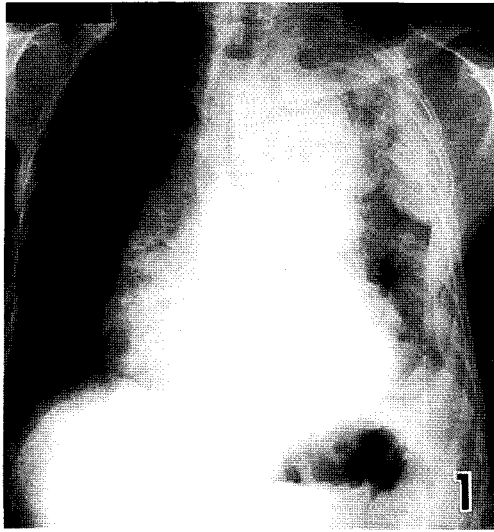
Chest X-ray film of Patient 1, a 69-year-old man.
